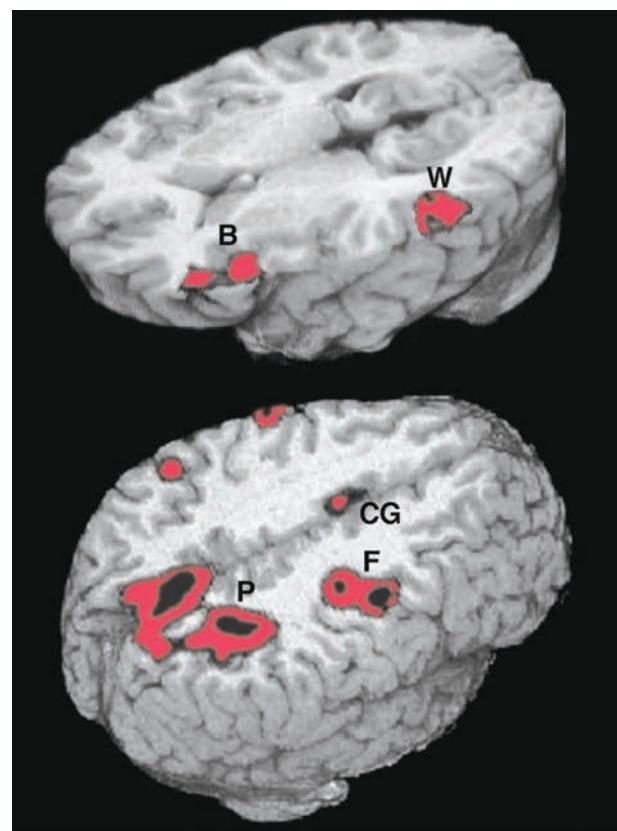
Functional magnetic resonance imaging of language and spatial attention in neurologically intact subjects. The red and black areas show regions of task-related significant activation. (Top) The subjects were asked to determine if two words were synonymous. This language task led to the simultaneous activation of the two components of the language network, Broca's area (B) and Wernicke's area (W). The activations are exclusively in the left hemisphere. (Bottom) The subjects were asked to shift spatial attention to a peripheral target. This task led to the simultaneous activation of the three epicenters of the attentional network: the posterior parietal cortex (P), the frontal eye fields (F), and the cingulate gyrus (CG). The activations are predominantly in the right hemisphere. (Courtesy of Darren Gitelman, MD.)
